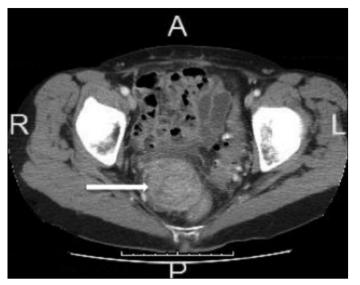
CT abd/pelvis with contrast. There is a heterogeneous right pelvis mass measuring 5.2×4.6 cm to the right of the rectum (mass indicated by white arrow)
